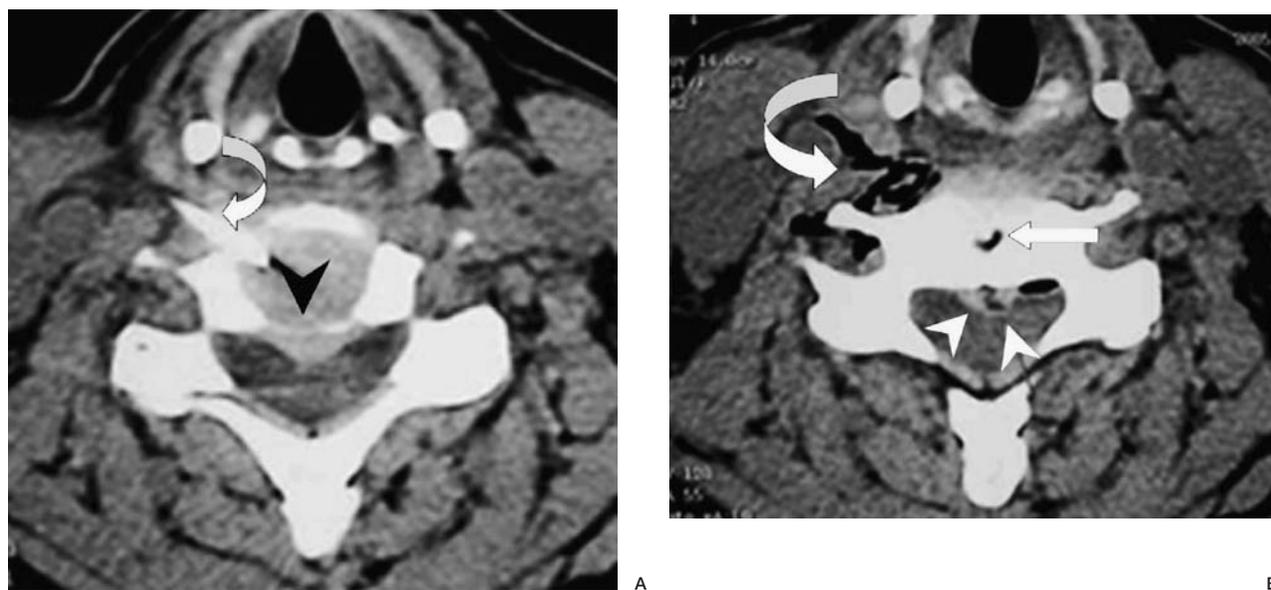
Images in a patient with C5-C6 midline disk herniation (myelopathic type). A) Precontrast CT image at the C5-C6 level shows disk herniation (*black arrow head*): the needle was introduced into the disk (*white curved arrow*) between the lateral margin of the thyroid gland and the medial margin of the cervical arterial sheath before ozone injection. B) After ozone injection, CT shows ozone distribution into the disk (*white arrow*), the herniated disk material (*white arrowheads*) and right paraspinal tissue and perivertebral arterial space (*white curved arrow*).
